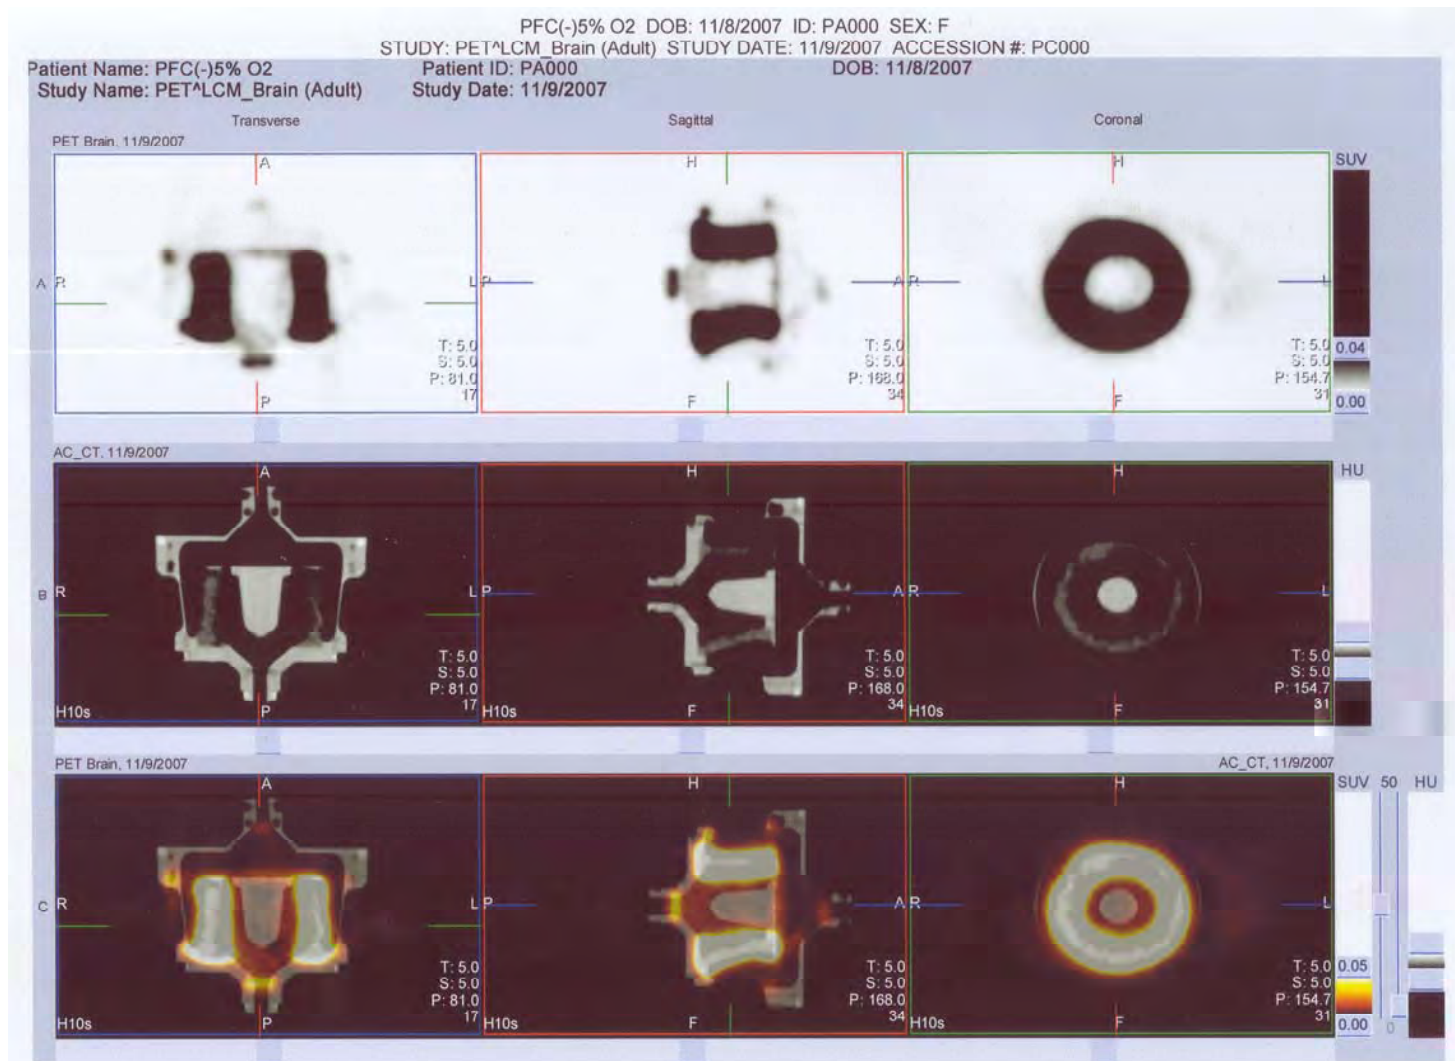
CT and PET scan of hypoxic gas mix cell-seeded bioreactor *without* PFC. The first row of images are PET only, the second CT only, the third is the combined CT (in black and white) and PET (in colour) images. The columns represent the transverse, sagittal and coronal planes respectively. The PET images of PFC(-) bioreactors were more radioactive or ‘hotter’, following greater glucose uptake, i.e. with a more glycolytic metabolism than the PFC(+) bioreactors.
